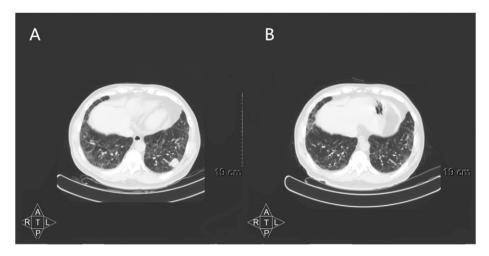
A is PET - CT result before chemotherapy, B is repeat PET-CT checked after chemotherapy.
